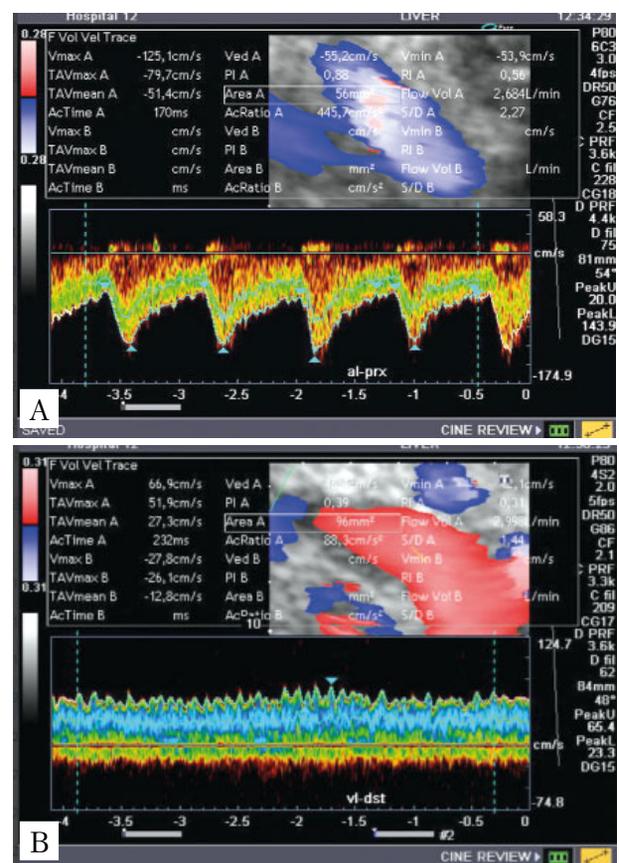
Doppler ultrasound flowmetry assessment: A. Splenic artery (AL) B. Splenic vein (VL). The image demonstrates the spectral Doppler waveform and the calculation of volumetric blood flow parameters in the splanchnic circulation
